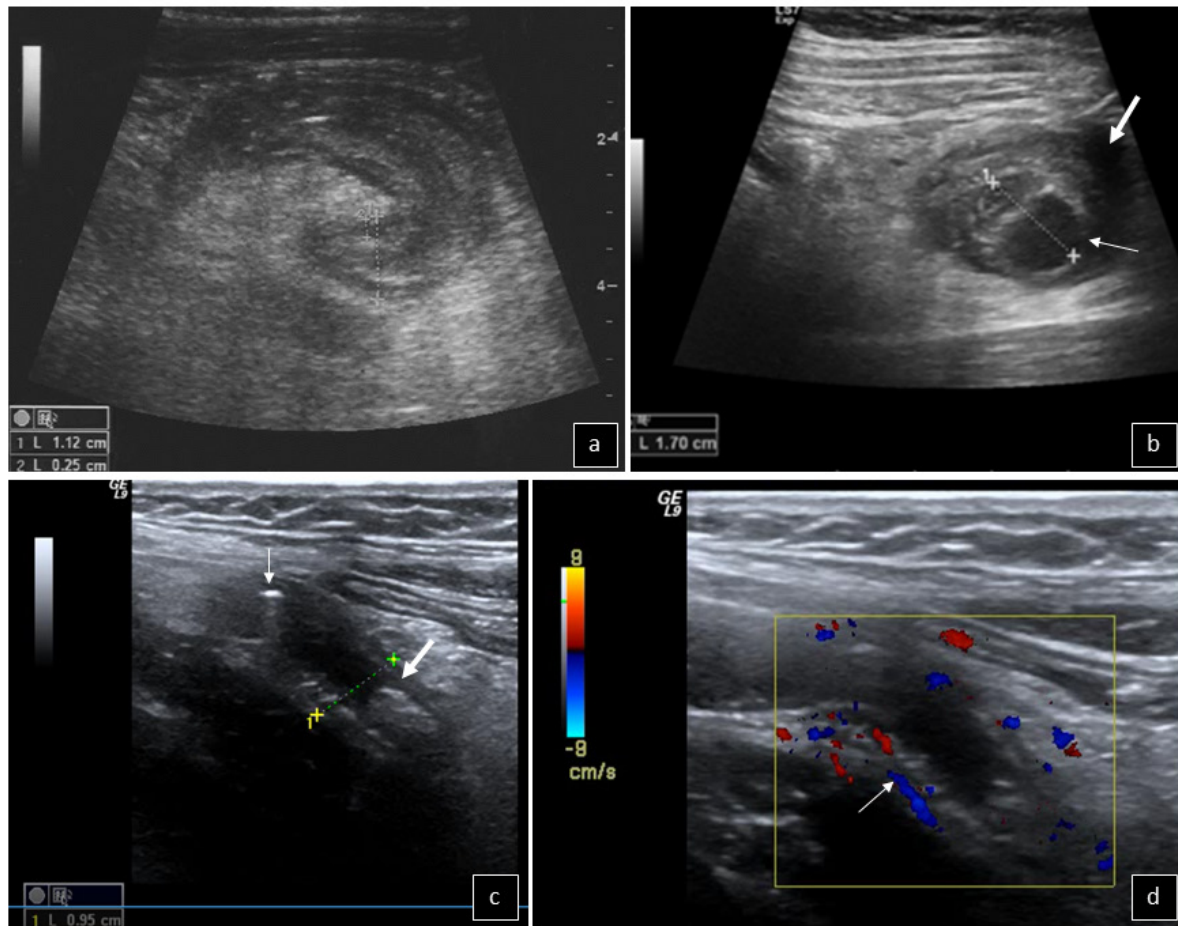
Different cases of appendicitis: a. Increased transverse diameter (1.1 cm) and thickened wall (0.25 cm), b. Loss of integrity (thin arrow) and fluid collection (thick arrow) due to rupture, c. Dilatation (0.95 cm), gas focus (thin arrow) and faecolith (thick arrow), d. Increased blood flow in the appendiceal wall (arrow) on colour Doppler.
